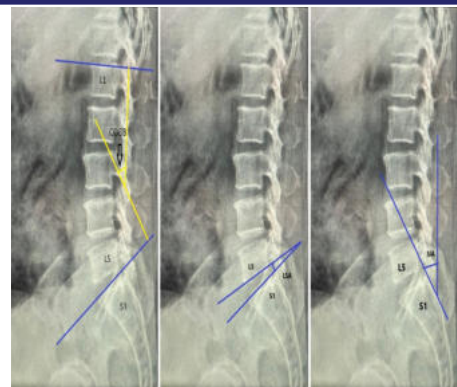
Lateral Radiographs showing measurement of LLA (Cobb angle), LSA and SIA.
